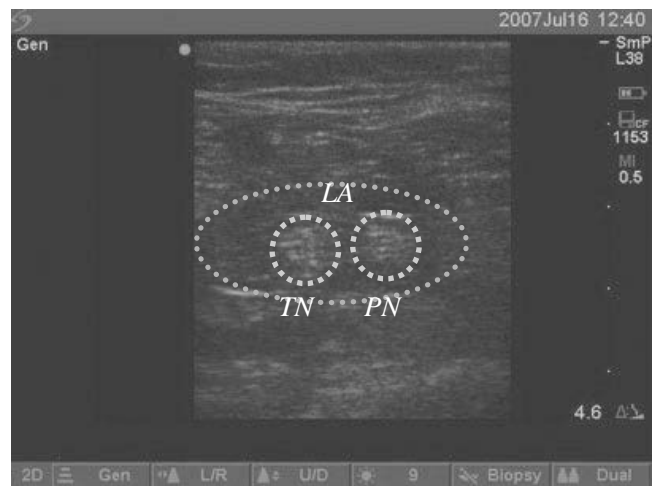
• Ultrasound-Guided Sciatic Nerve Block. Image showing the two parts (tibial and common peroneal) of the sciatic nerve in the proximal popliteal fossa surrounded by local anesthetic. TN, tibial nerve; PN, common peroneal nerve; LA, local anesthetic.
